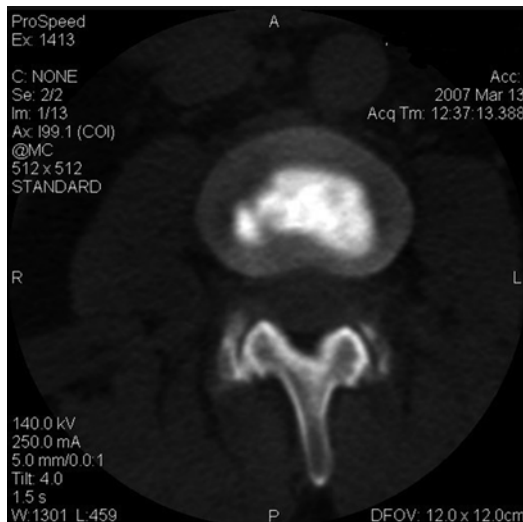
Axial post-diskography CT scan with grade 1 and 2 annular tears. Contrast extends slightly into the inner annulus in the right posterior quadrant and into the middle annulus in the left posterior quadrant
